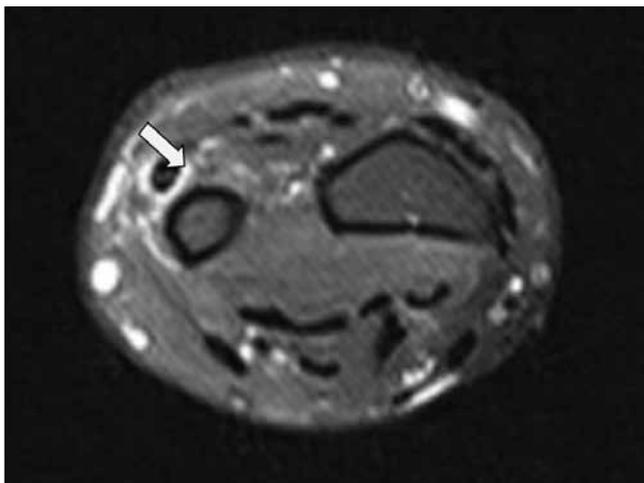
White arrow in T2-weighted MRI appearance of tenosynovitis in wrist.
